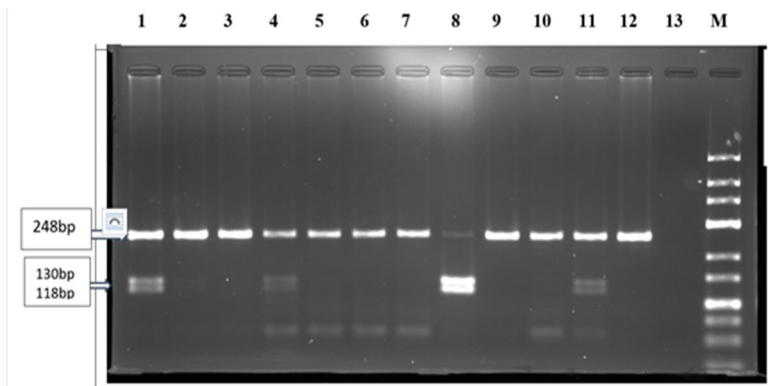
Shows the gel electrophoresis of the genotypes of the *MTHFR* polymorphism (rs1801133). Lane 1,4,8 and 11 are heterozygous mutant (CT genotype). Lane 2,3,5,6,7,9,10 and 12 un cleaved wild-type homozygous (CC genotype). Lane M = 25 bp DNA marker.
